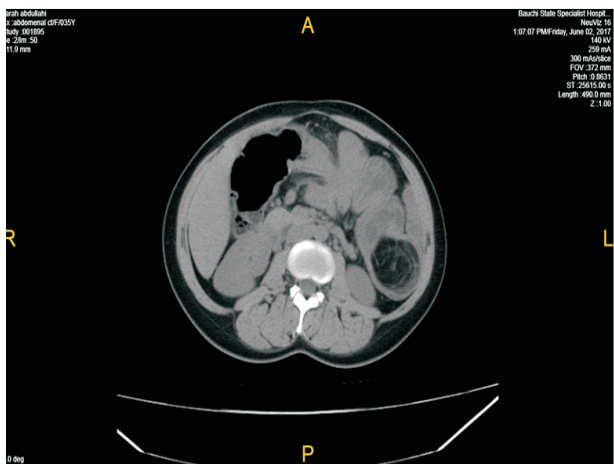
AXIAL COMPUTED TOMOGRAPHIC SCAN IMAGE AT THE LEVEL OF PART THE KIDNEYS SHOWING A ROUNDED DEFINED NON ENHANCING HYPODENSE MASS OF FAT DENSITY WHICH APPEARS TO BE WITHIN THE COLONIC LOOP IN THE LEFT UPPER QUADRANT CLOSE TO THE LEFT KIDNEY, NO BOWEL DILATATION SEEN. (intrabdominal lipoma –bowel origin)
